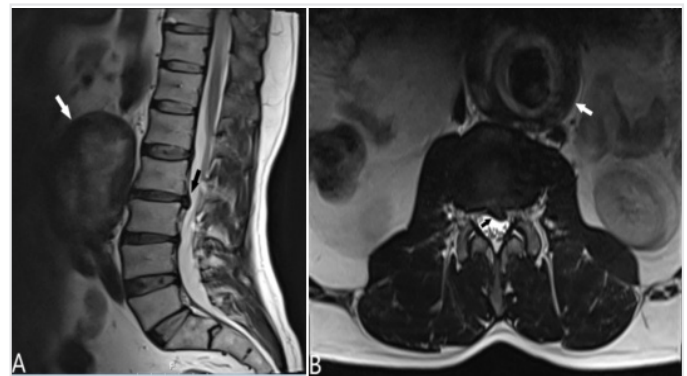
Preoperative T2-sagittal (A) and T2-axial (B) magnetic resonance images showing abdominal aortic aneurysm (AAA) (white arrow) and L2-3 extruded disk herniation (black arrow)
